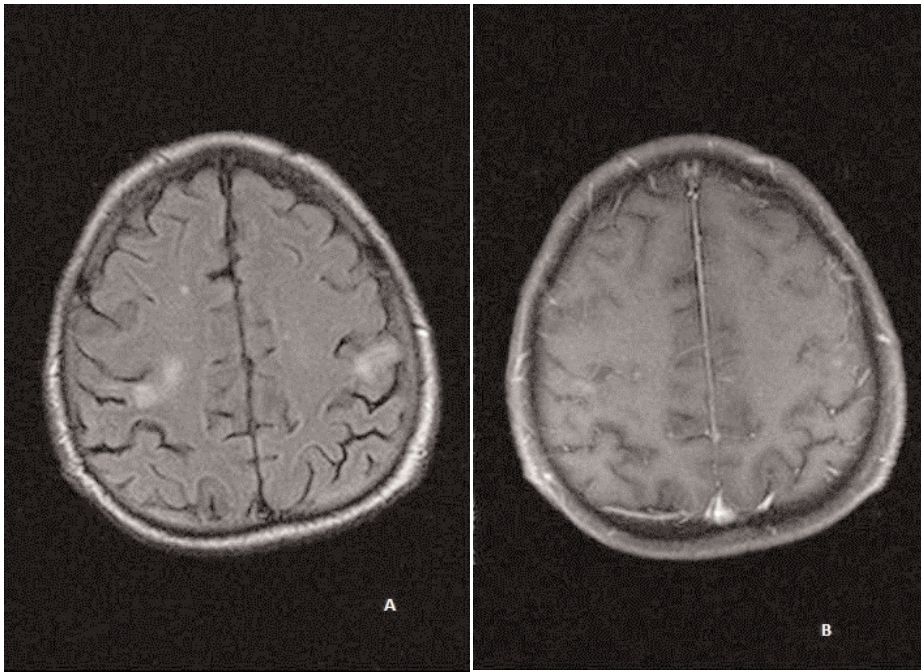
Follow up brain MRI, A-Fluid Attenuation Inversion Recovery (FLAIR) sequence; B-post contrast T1 Weighted Image (WI), showed complete regression of focal lesions and surrounding edema in parietal lobes bilaterally
